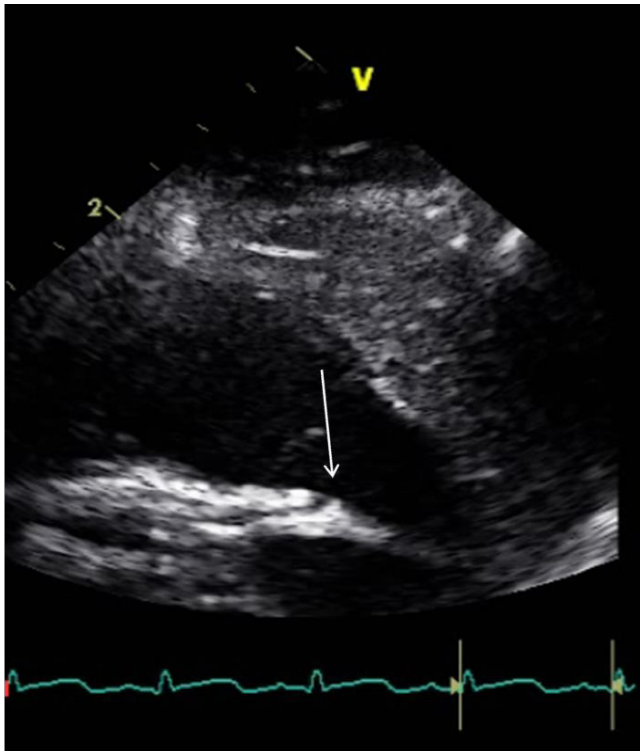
Transthoracic echocardiography in the modified short-axis view shows the orifice of a normal-sized right coronary artery (arrow) arising from the main pulmonary artery.
